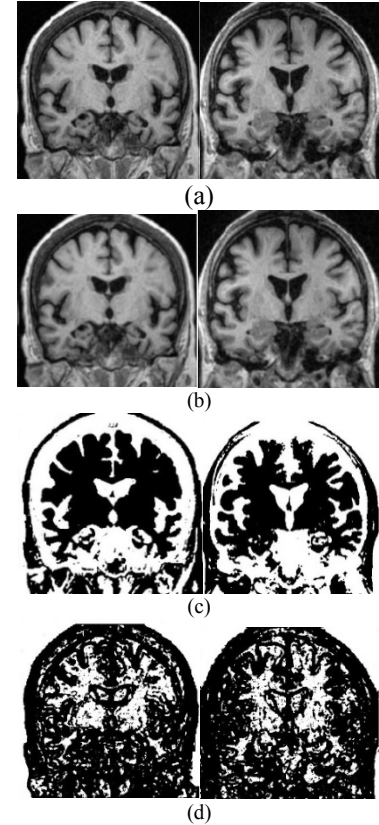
MR image processing of normal and AD subjects. First column represents MRI of normal subject and second column represents MRI of AD subject. (a) Original MR images. (b) Filtered images. (c) Segmented gray matter. (d) Segmented white matter
